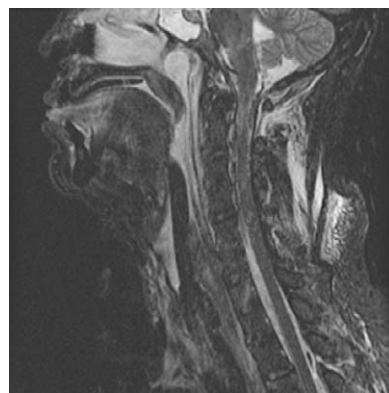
Sagittal STIR image demonstrates extensive soft tissue and ligamentous injury with increased signal intensity throughout the posterior paraspinal musculature, interspinous ligaments, and prevertebral space. A distraction injury at C1-2 was suspected and verified on additional sequences and on CT. There is signal abnormality at the pontomedullary junction and within the spinal cord at C2.
